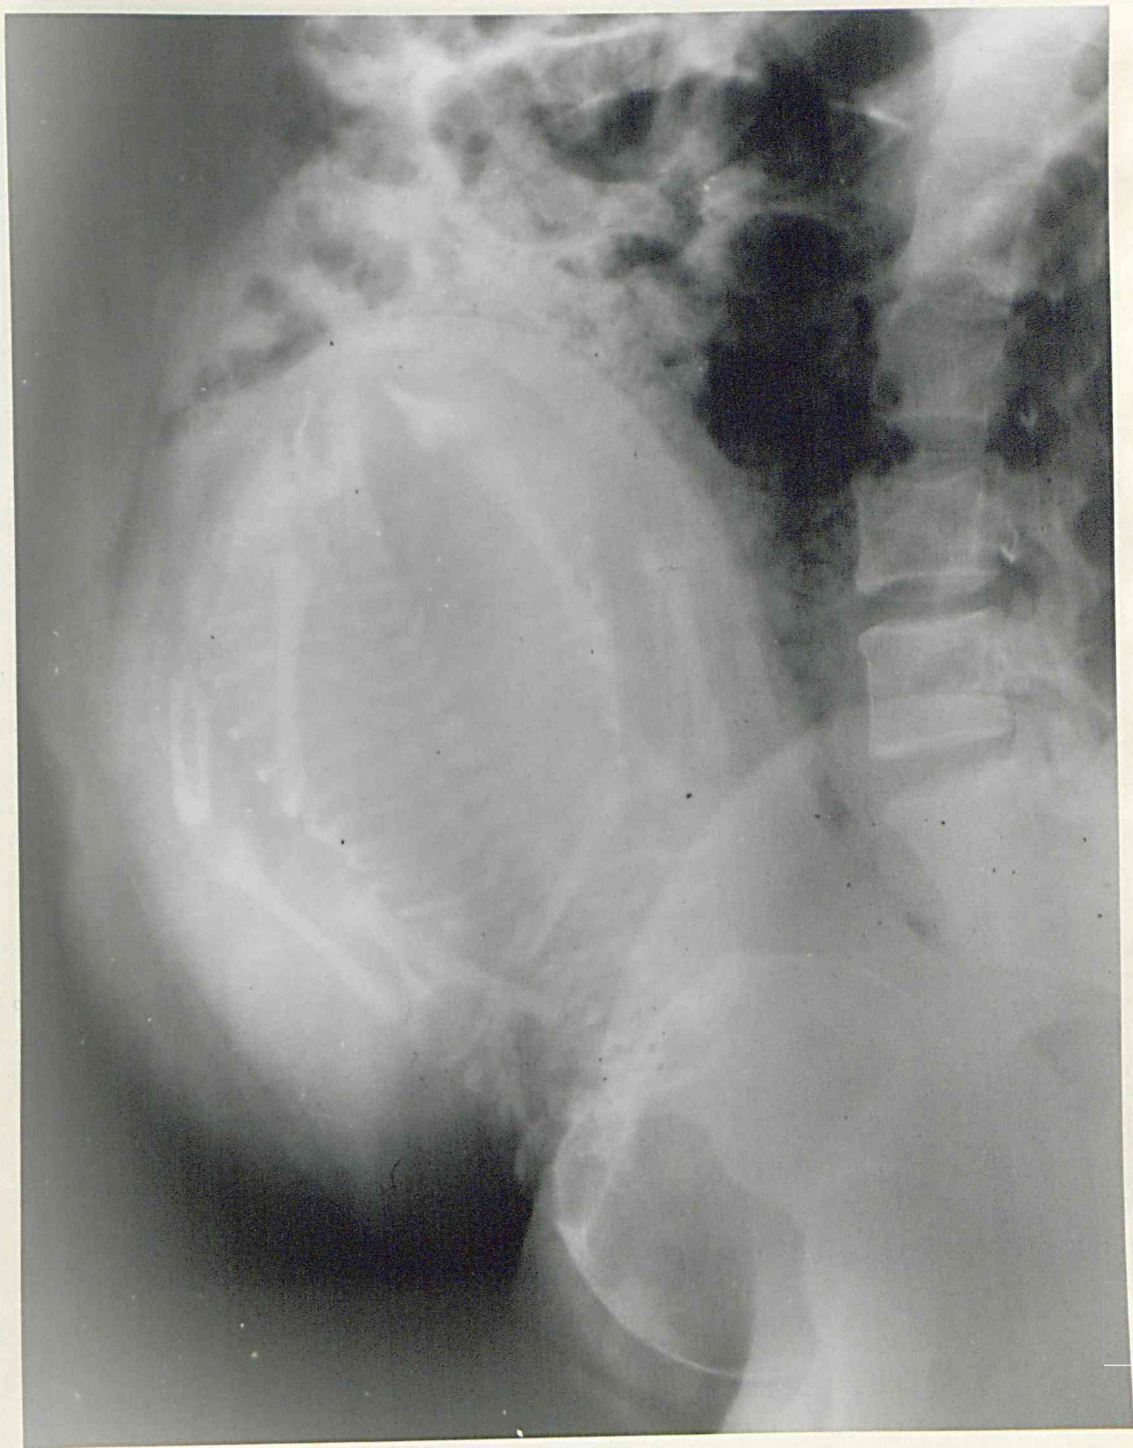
The lateral radiograph of the abdomen in a case of implantation of the placenta on a lateral wall of the upper uterine segment. There is no diagnostic unilateral thickening of the soft tissue shadow. Oblique radiographs in this case demonstrated the site of the placenta. (Case No. 163).
